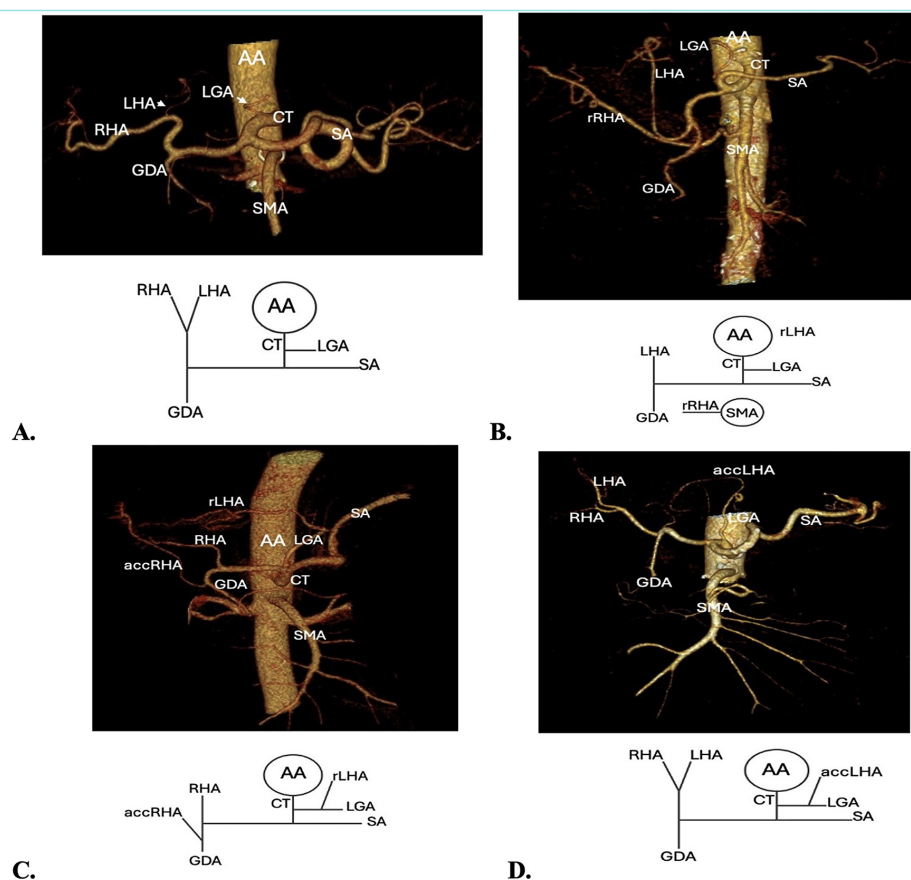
A. Type 1a shows abdominal aorta (AA), celiac trunk (CT), splenic artery (SA), left gastric artery (LGA), superior mesenteric artery (SMA), left hepatic artery (LHA), right hepatic artery (RHA), and gastroduodenal artery (GDA). B. Type 1b shows AA, CT, SA, LGA, SMA, LHA, replaced right hepatic artery (rRHA), and GDA. C. Type 1c shows AA, CT, SA, LGA, SMA, RHA, replaced left hepatic artery (rLHA), accessory right hepatic artery (accRHA), and GDA. D. Type 1f shows AA, CT, SA, LGA, accLGA, LHA, RHA, and GDA.
